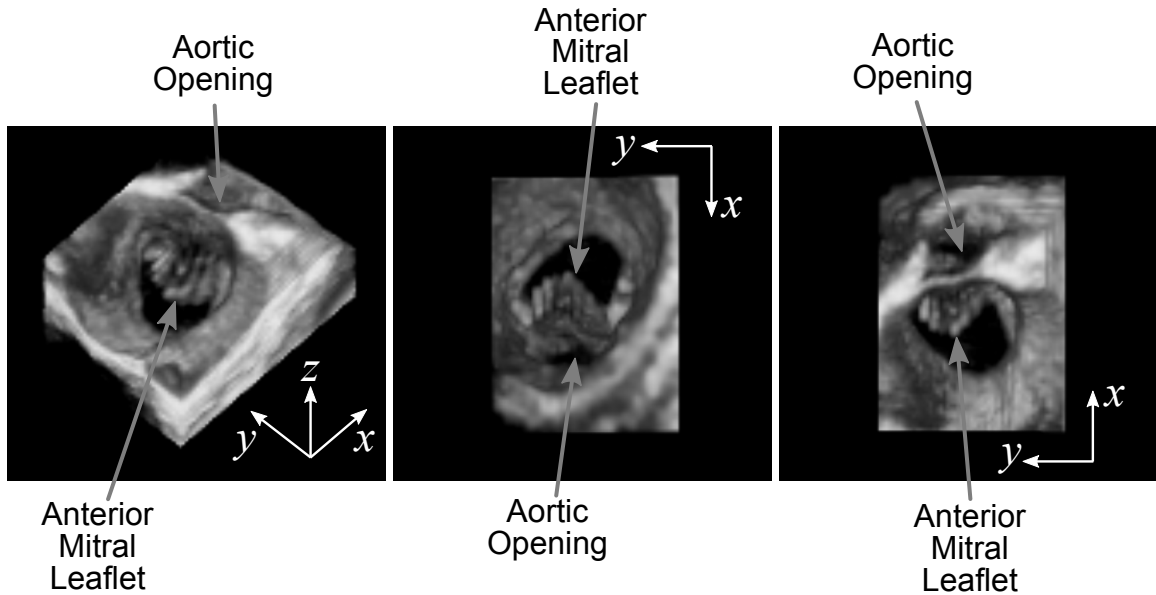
Clinical ultrasound of a mitral valve which showing the location of the scan fans at the anterior mitral leaflet in (Left) an isometric view from above the valve, (Middle), a view looking up at the valve from the left ventricle, and (Right) a view looking down on the valve from the left atrium. The locations of the scan fans are characterized by the striped appearance of the anterior mitral leaflet. The fact that the stripes are directed in the  $x$ -direction indicates that the scan fans are rotated about an axis parallel to the  $x$ -axis.
